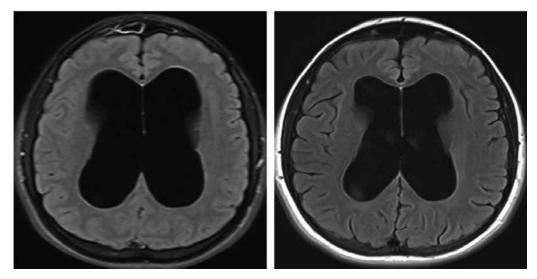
Axial constructive T1W1 MRI demonstrating a reduction in the volume of the lateral ventricles at postoperative MRI (right) compared to preoperative MRI (left).
